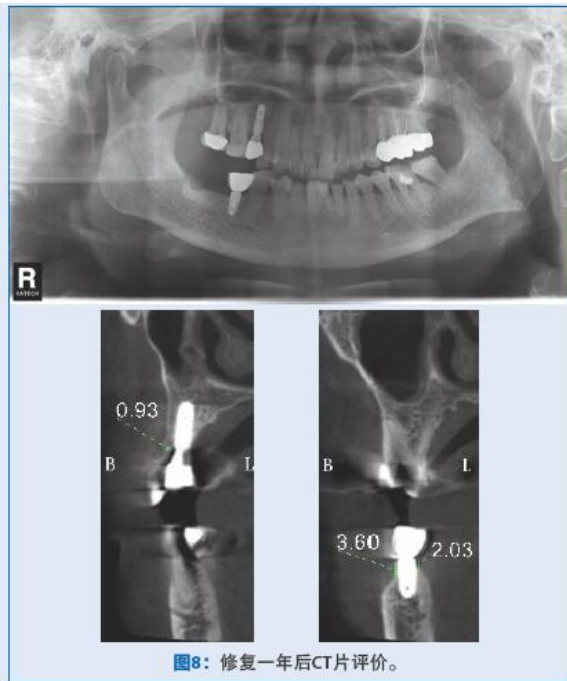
Assessment by CT 1 year after restoration.
